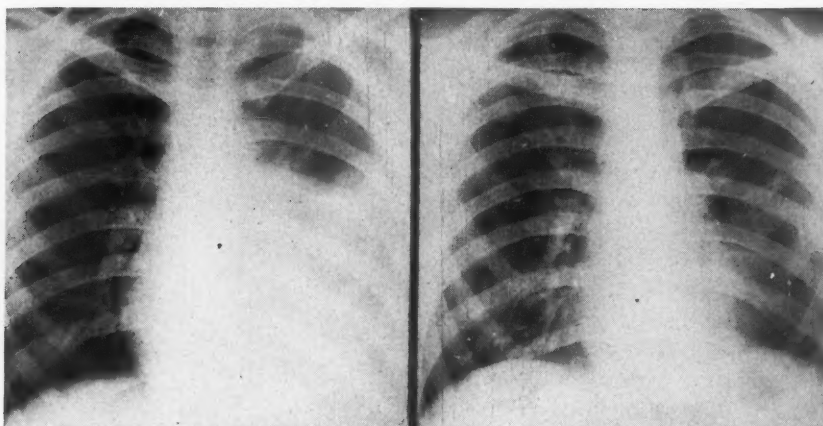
Case 9: Roentgenogram on October 26 shows a massive hemothorax following a through-and-through bullet wound on October 5. Roentgenogram on November 17 shows complete clearing of the lung and pleura without need of aspiration.
